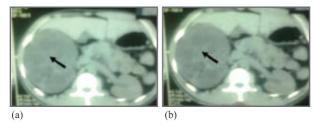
(a, b): CT scan of abdomen (non contrast) showing multiple cyst in right kidney, replacing normal renal parenchyma and unremarkable left kidney, liver, spleen and other abdominal organs.
